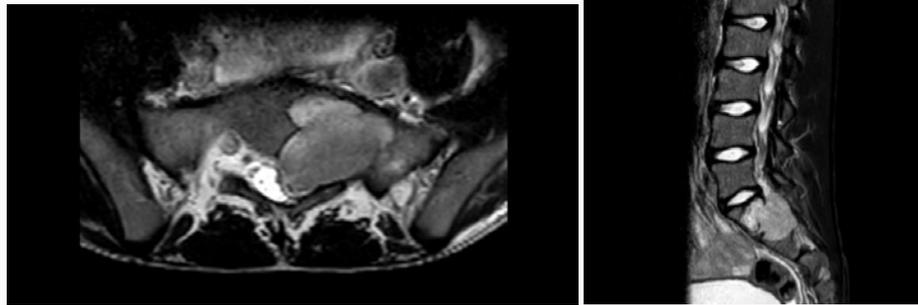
Axial and sagittal slice from preoperative MRI where a lesion had increased signal intensity at STIR sequence and heterogeneous gadolinium-enhanced T1 image, suggestive of Schwannoma.
